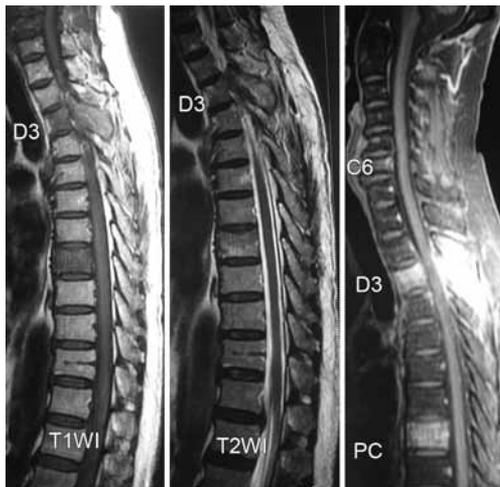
Sagittal MRI spine showing noncontiguous involvement of C6, D3 and D8 vertebra
